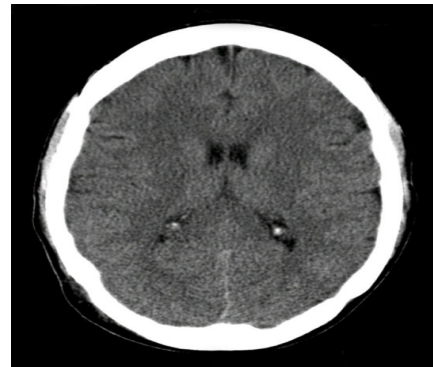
(a)- CT scan of a normal person
